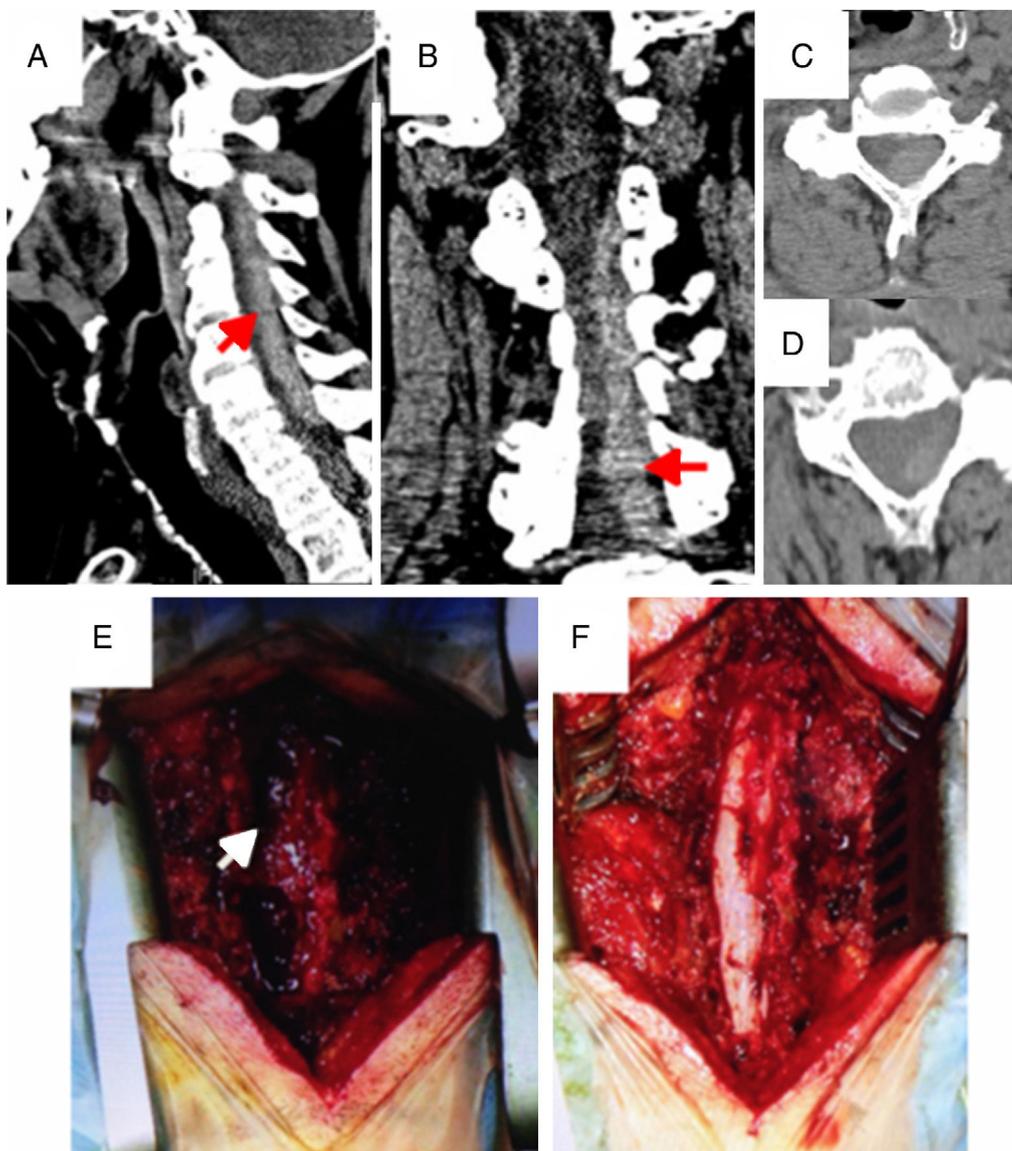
Presurgical images from the emergency cervical CT scan. Sagittal (A), coronal (B), and axial (C and D) slices revealing the presence of an extensive hyperdense collection at the left posterolateral epidural level C3-C7 (arrows), compatible with SAEH. This collection causes a pronounced reduction of the spinal canal and displacement of the spinal cord to the right. Images after C3-C7 cervical laminectomy showing the previously described acute cervical epidural collection at the left posterolateral level (E). Image during surgery after complete evacuation of SAEH (F).
